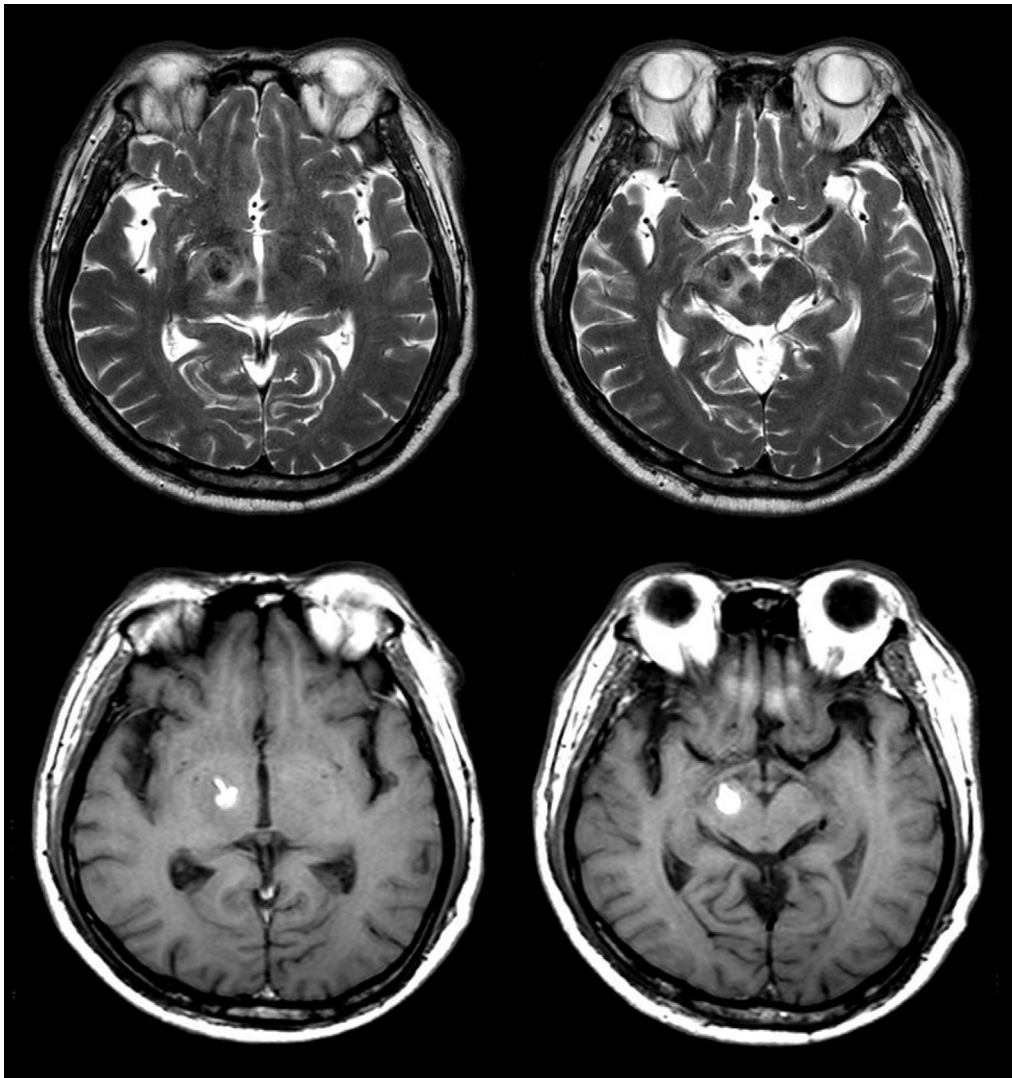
Axial T2-weighted MRI (upper row) and T1-weighted MRI (lower row) showing acute focal hemorrhage in the right subthalamic area.
